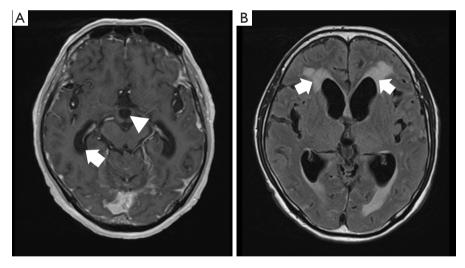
This image shows the signs of hydrocephalus, with ventricular enlargement evident early in the lateral and third ventricles, and areas of water infiltration in the anterior horns of the lateral ventricles as hydrocephalus progresses. (A) T1WI-MRI demonstrates early signs of hydrocephalus in the third ventricle (arrowhead) and inferior horns of the lateral ventricle (arrow). (B) FLAIR MRI demonstrates ventricular enlargement in the anterior horns of the lateral ventricle with a periventricular high-intensity area (arrows). T1WI, T1-weighted image; MRI, magnetic resonance imaging; FLAIR, fluid-attenuated inversion recovery.
